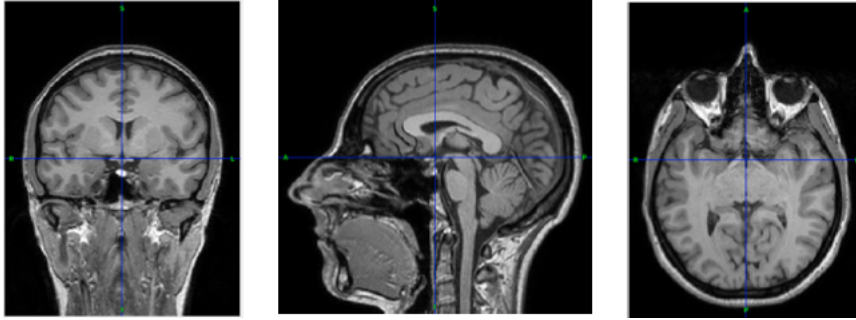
MRI slices acquired using alternative directions in space.
